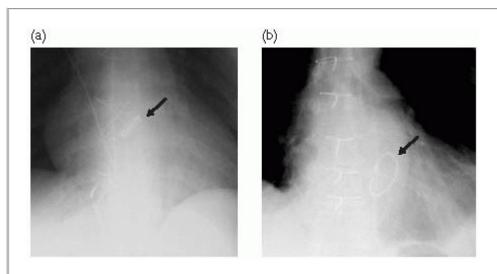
Close-ups of radiographs showing: (a) Aortic valve replacement. (b) Mitral valve replacement.
